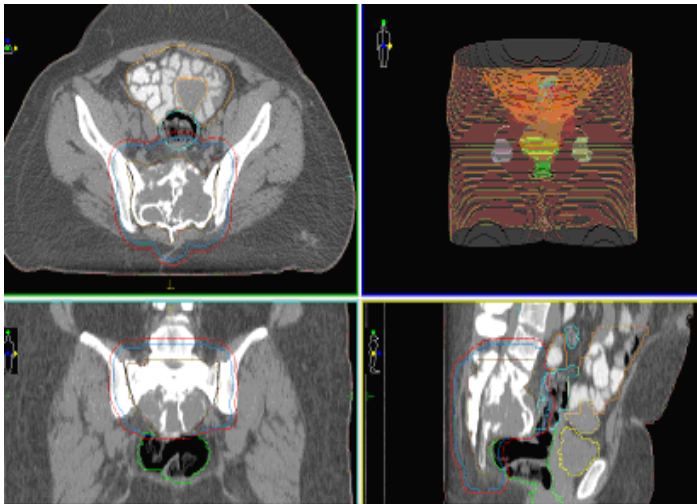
Localization CT of a sacral giant cell tumor with delineation of the radiotherapy volumes (CTV and PTV) before the radiotherapy.
